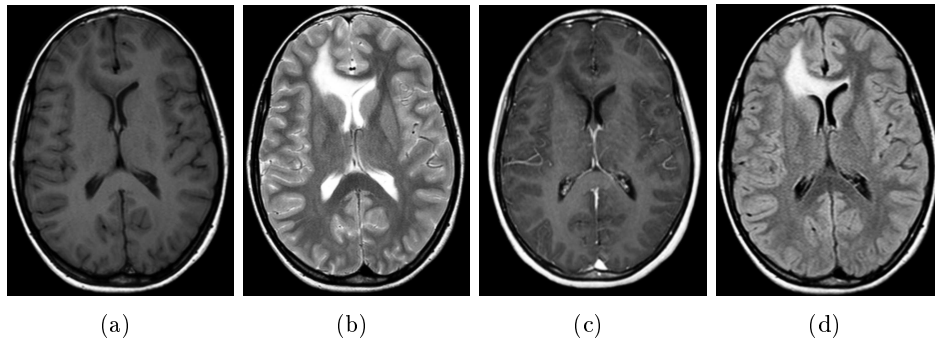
In the images above we show axial slices of (a) T1-weighted, (b) T2-weighted, (c) T1-weighted post gadolinium injection and (d) FLAIR images of a pediatric patient with a diffuse astrocytoma of grade II. We see that the tumor is enhanced in the T2-weighted and the FLAIR images.
